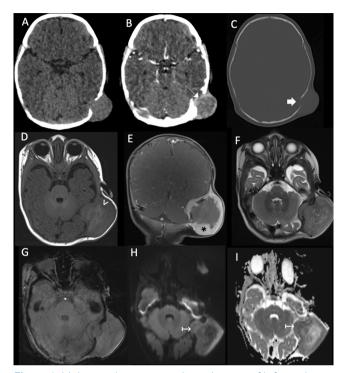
Melanocytic neuroectodermal tumor of infancy, in a two-month-old infant who presented with a mass over the left mastoid fontanelle. Axial pre and post contrast CT scans (A–C) showed an apparently extracranial mass at the level of the left mastoid fontanelle, with peripheral enhancement (thin white arrow in B) and osteolytic and remodeling bone changes (thick white arrow). MRI images (D–I) demonstrated a predominantly extracranial heterogeneous mass with intra and extracranial components, hyperintense areas on T1WI (white arrowhead in D) and avid peripheral contrast enhancement (* in coronal image in E). No magnetic susceptibility artifacts were observed on SWI (G). In DWI and ADC (H and I), some deep areas of restricted diffusion were presented (\mapsto).
